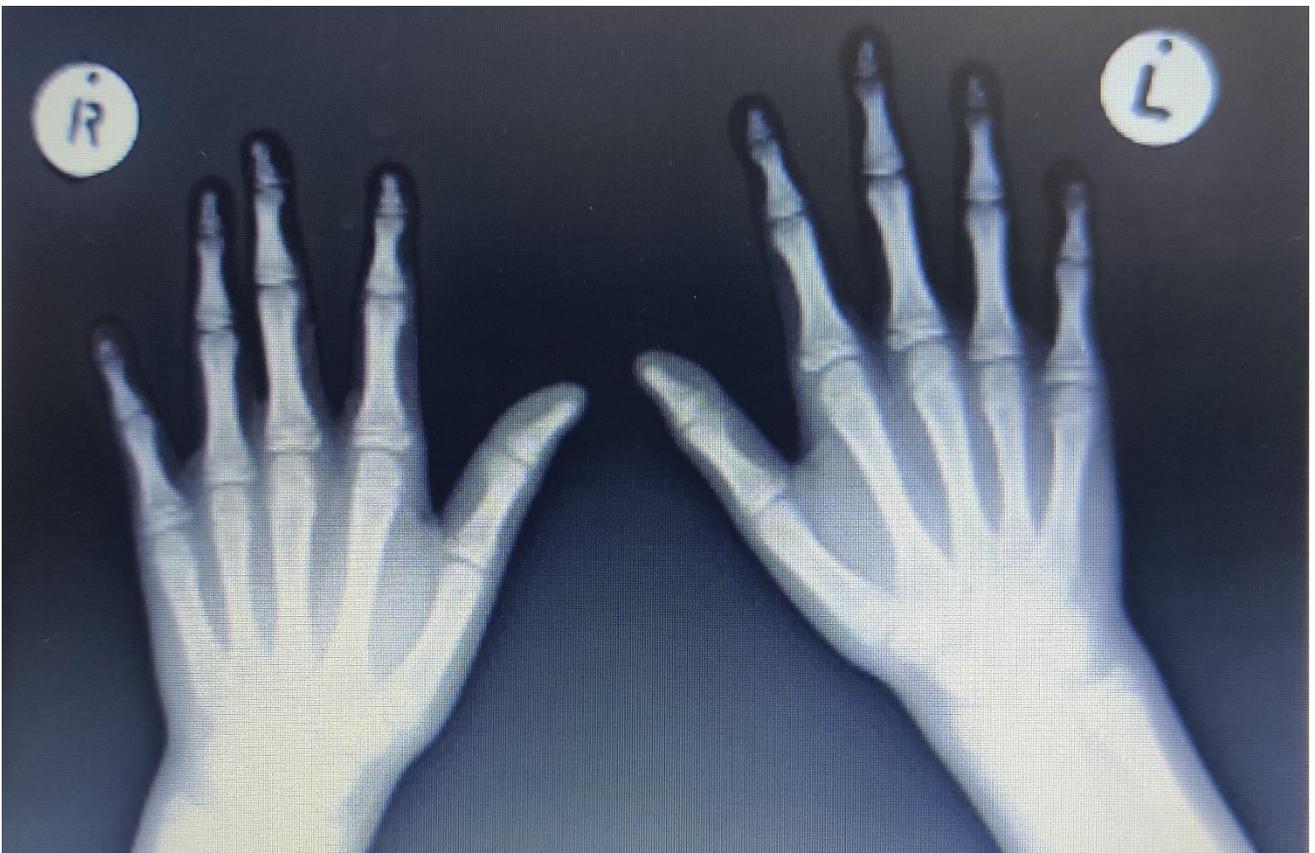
Radiograph of both hands confirming longitudinal acro-osteolysis.
